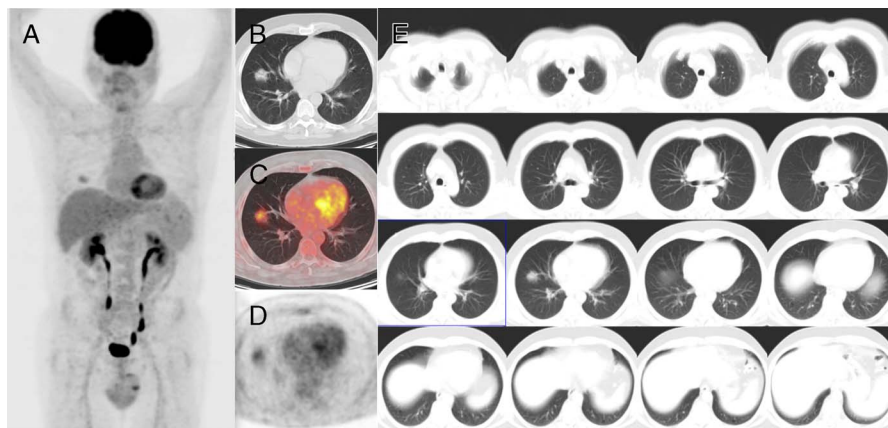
A 59-year-old man with diffuse large B-cell lymphoma on whom an ^{18}F -FDG PET/CT was performed for immunochemotherapy response evaluation on March 18, 2020, 27 days after COVID-19 outbreak in Italy. Along with partial metabolic response, PET maximum intensity projection image (A) revealed a focal uptake area in the middle field of the right lung, corresponding on axial images (B, low-dose free-breathing coregistered CT; C, fused PET/CT; D, PET only) to a metabolically active (SUVmax 3.3) isolated centrilobular consolidation in the middle lung lobe surrounded by a faint ground-glass opacity (GGO) (maximum diameter 28 mm), without any other parenchymal alterations detectable bilaterally at coregistered CT (E). At that time, the patient was considered at low risk of SARS-CoV-2,¹ being completely asymptomatic and denying suspected expositions to infected people. Based on clinical and morphofunctional characteristics, the PET/CT finding was interpreted as a nonspecific pneumonia at an early phase, as frequently occurring during chemotherapy. A subsequent clinical/radiological evaluation was suggested. On March 30, still asymptomatic without specific medication, the patient underwent a chest x-ray for reevaluation, showing bilateral parenchymal consolidations, highly suggestive of viral pneumonia. He suddenly was tested for SARS-CoV-2 through nasopharyngeal swab, resulting as positive, and he was quarantined at home.
